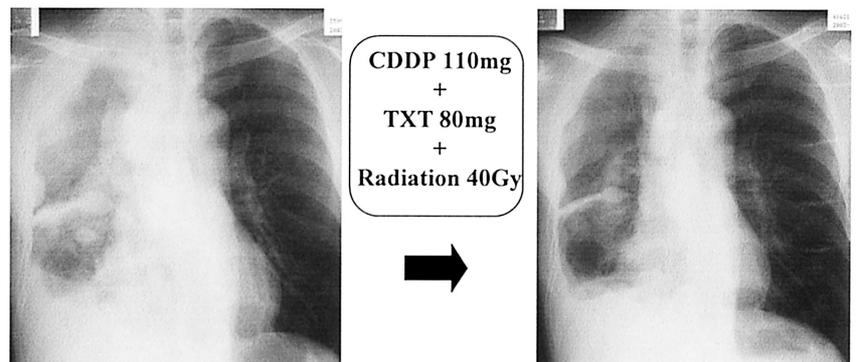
The findings of the chest X-ray of the case No. 6 before and after induction therapy.
